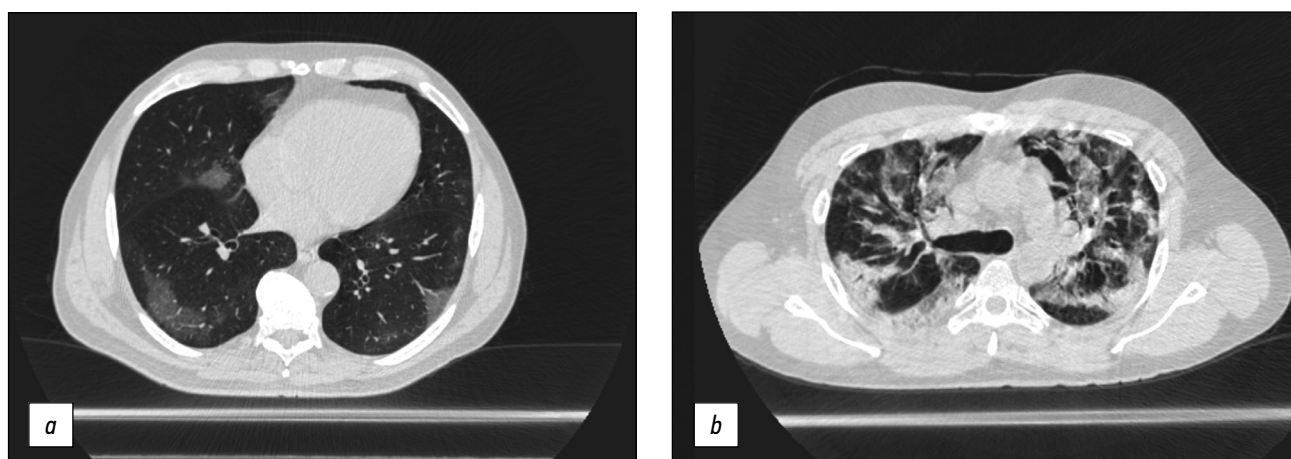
Axial computed tomographic slices of chest organs in the lung window: (a) polymorphic, predominantly subpleural areas of ground-glass opacity, corresponding to the CT image of viral pneumonia (including COVID-19), CT-1, and (b) multiple polymorphic areas of parenchyma compaction with a tendency to merge, with ground-glass opacity areas and mild reticular changes, CT-3.
